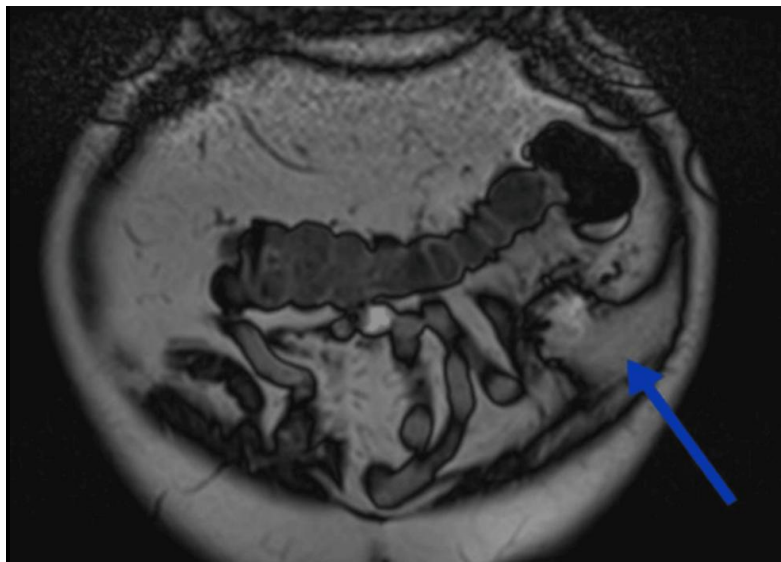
Coronal view of MRI abdomen with blue arrow pointing at the lesion
